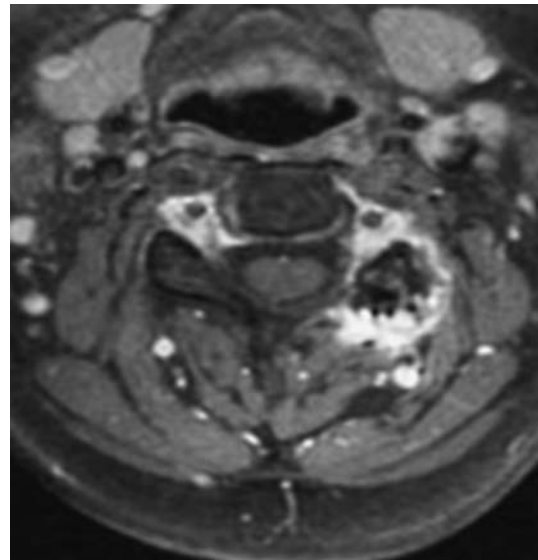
Reiter's syndrome of the cervical spine. Axial fat-suppressed T1-weighted image after gadolinium contrast administration. Note unusual involvement of the left facet joint, demonstrating irregular delineation and enhancement on both sides of the joint space
